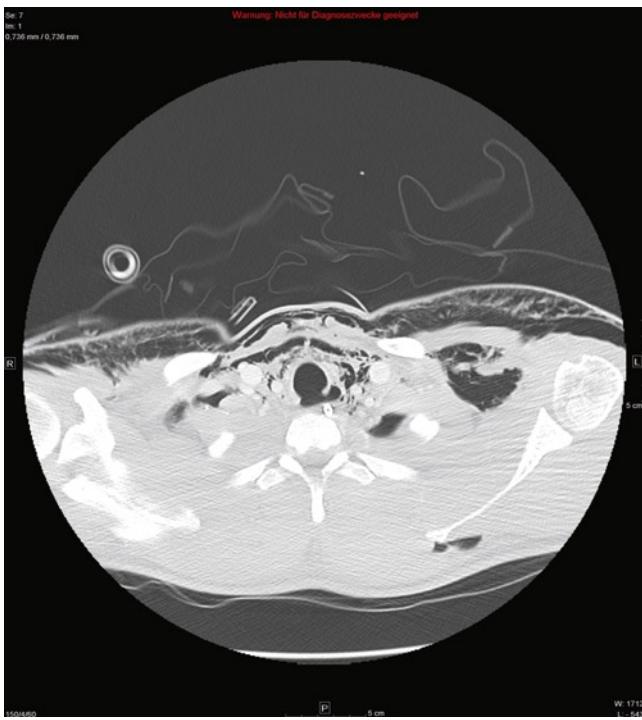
CT scan thorax of a male patient with severe traumatic tracheal rupture, mediastinal emphysema.
